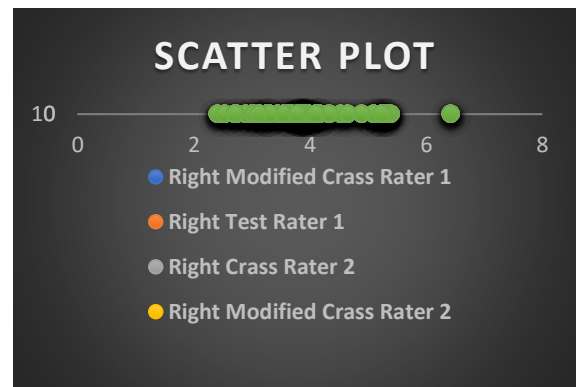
Correlation between tendon thickness measured by ultrasound by two raters and tendon thickness by MRI in right hand
